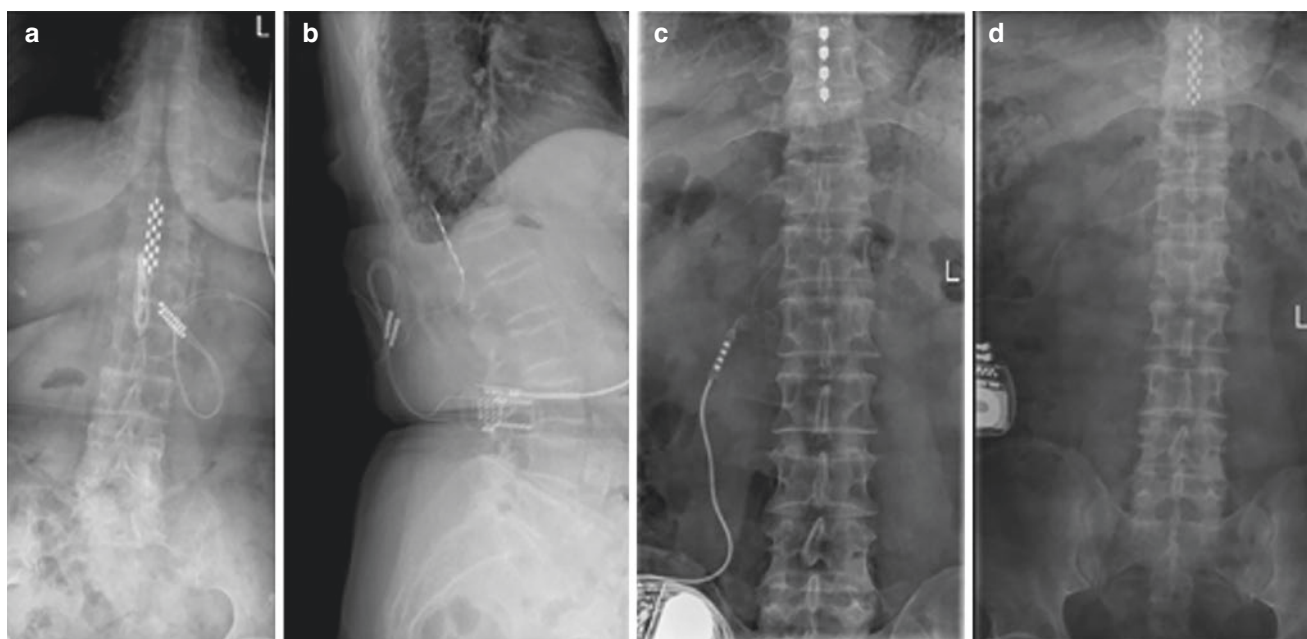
Postoperative radiographic findings of SCS in anterior and lateral positions. (a, b) Anteroposterior and lateral lumbar vertebrae showed the implantation of 3 rows of 16-contact SCS electrodes connected with extension wires; (c) the patient received 4-contact electrode
